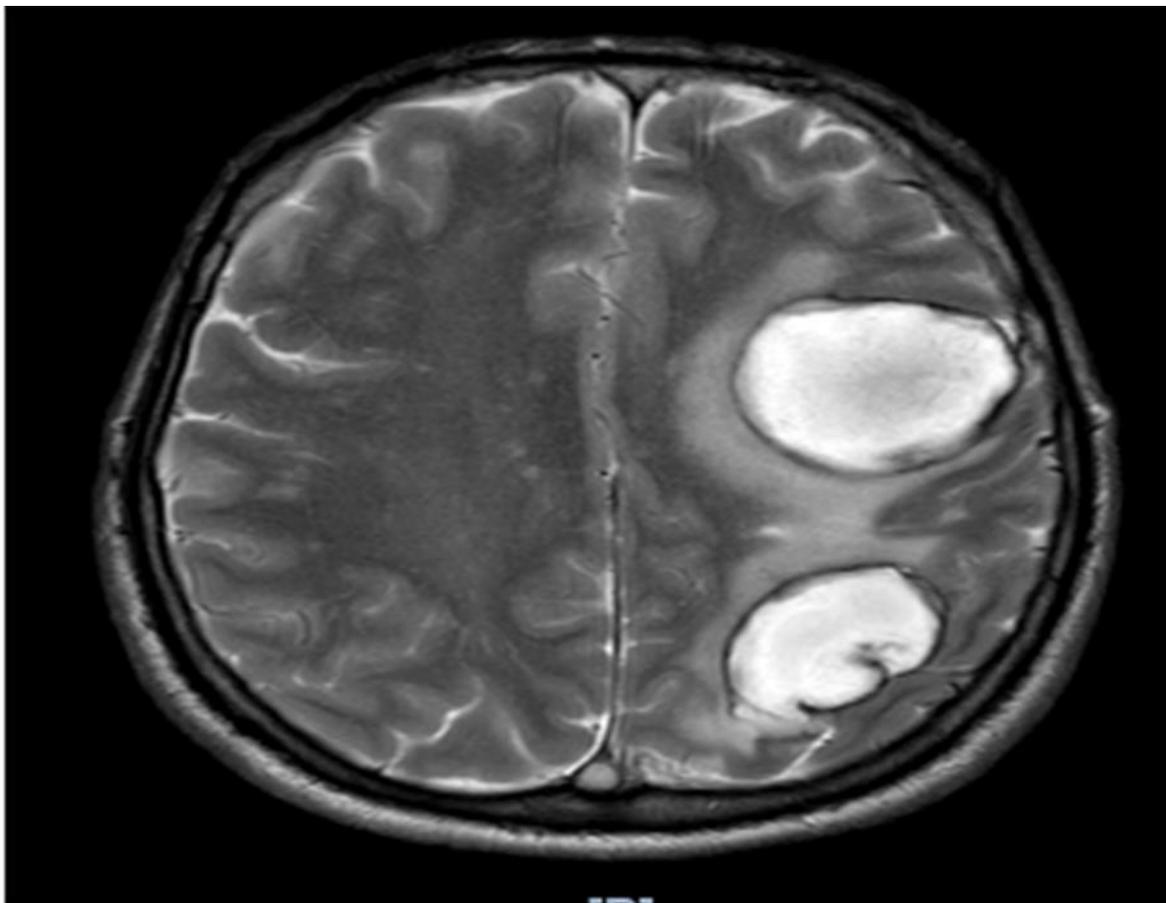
MRI showing two atypical subacute intracerebral hematoma in the left frontal and in the left parietal lobe
